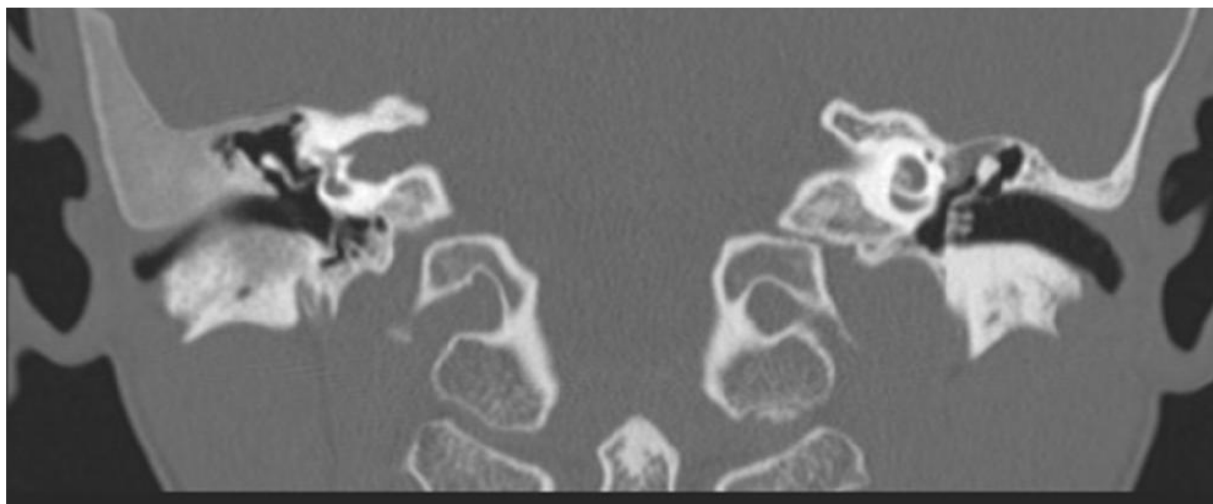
High-resolution CT scan image showing ground glass opacification and expansion of petrous temporal bone on the right.
